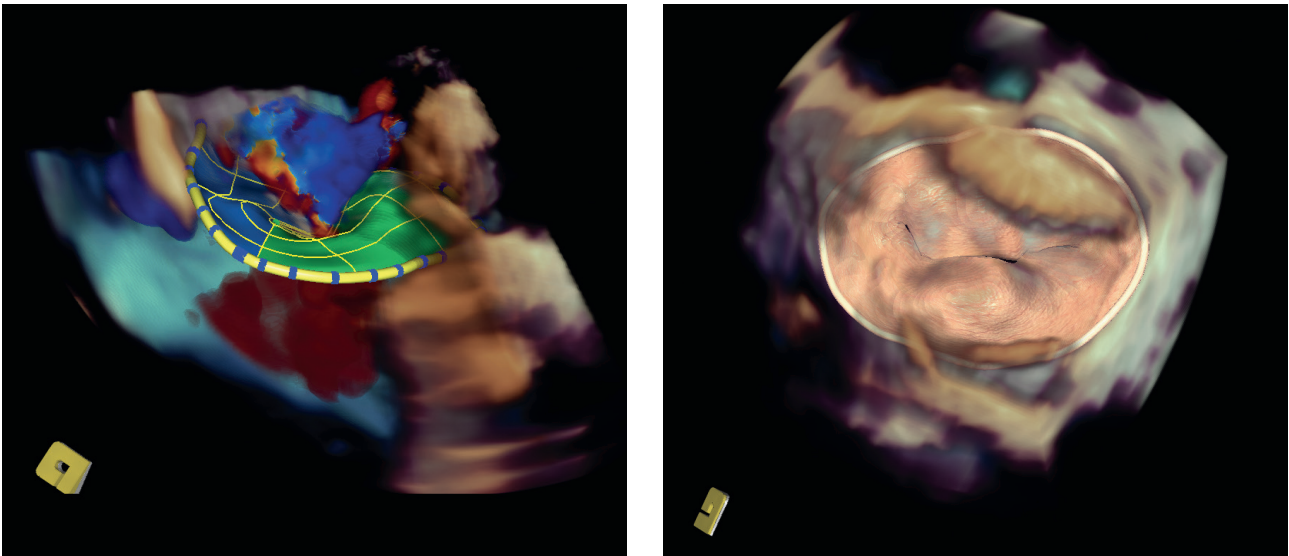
Left: Simultaneous B-Mode and Color Doppler images of a mitral valve in a patient suffering from Barlow's disease. One can clearly see the regurgitant jet. Right: Realistic rendering of the model estimated with the eSie Valves package, exhibiting typical features of Barlow's disease: posterior prolapse, enlarged annulus.
